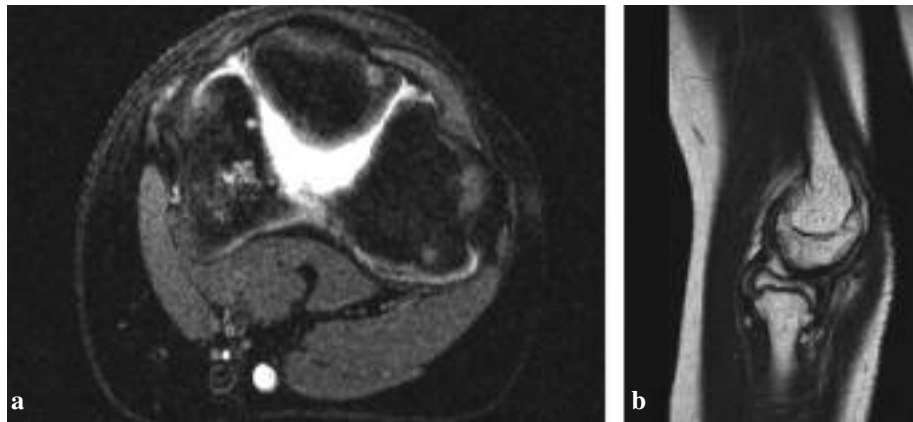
Coronal (a) and sagittal (b) MRI of the distal humerus demonstrate necrosis of the trochlea and radial head
